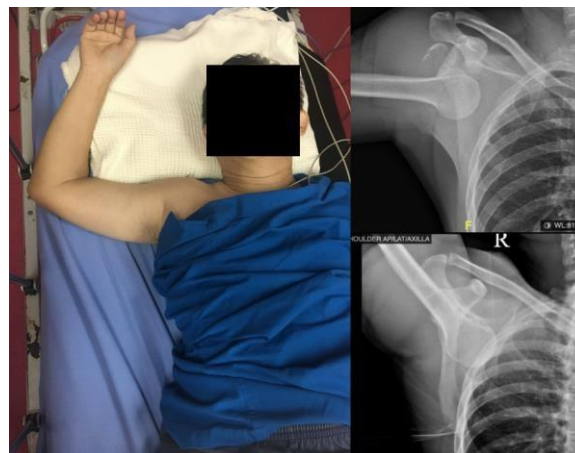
Hyperabduction of right arm (left) and X-Ray of right shoulder (right) pre-reduction.
